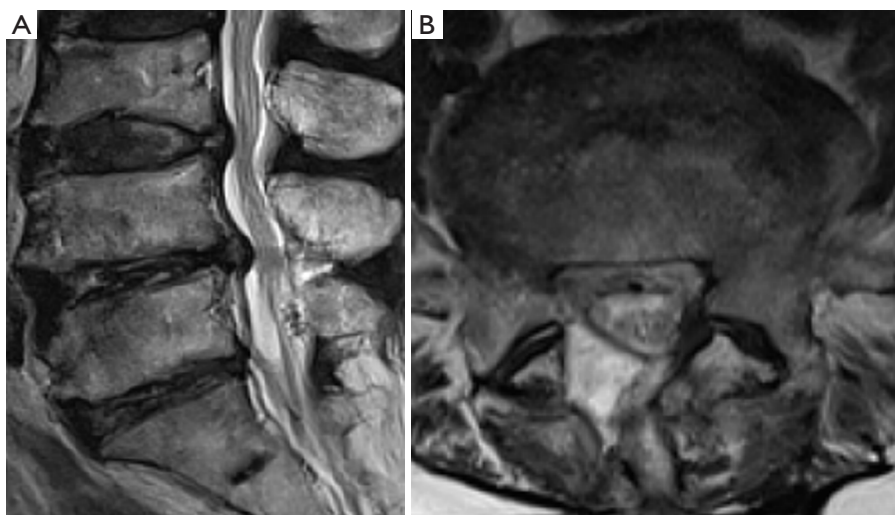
A month after surgery, the patient's sagittal (A) and axial (B) magnetic resonance images show total resolution of the previous hematoma.
